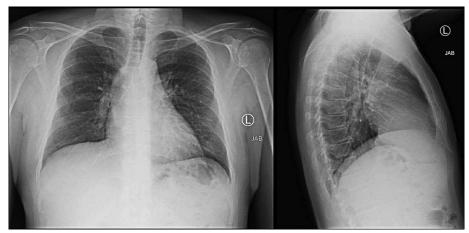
A posteroanterior and lateral chest x-ray obtained on patient initial presentation.
